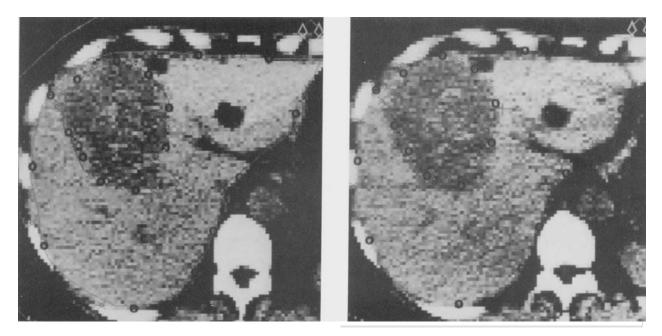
Check of reproducibility. The left panel shows a study one week before treatment and the right panel a study one hour before treatment. A transform between the two studies was defined with the sterotactic system. The comparison of the two CT slices was made by defining the crosses in the left slice, that were transformed to the right slice.
